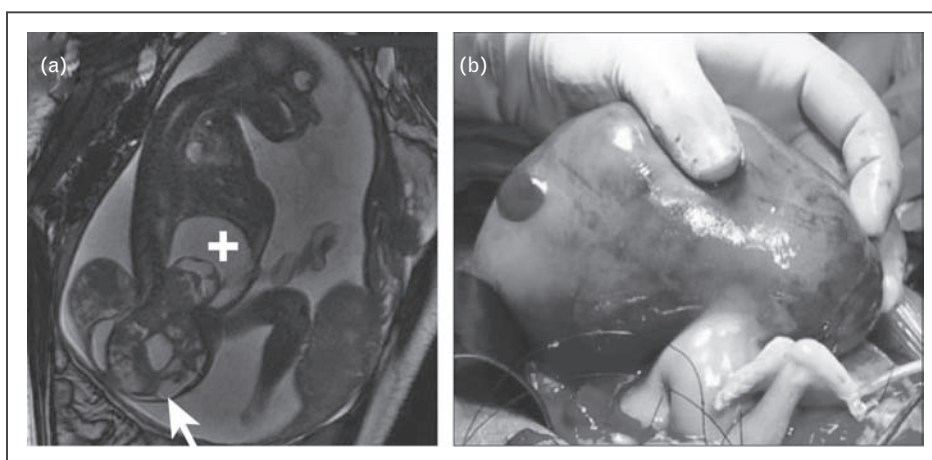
(a) Fetal MRI demonstrating a large solid and cystic presacral mass with an extensive extrapelvic component (arrow) in conjunction with intra-abdominal extension (plus sign). (b) In-utero resection for a fetus with a large sacrococcygeal teratoma associated with early signs of hydrops, placentomegaly, and impending high output cardiac failure.
